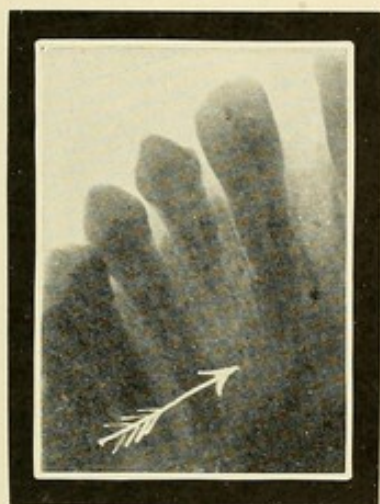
X-ray in dentistry. Shows absence of the germ of the permanent tooth.
